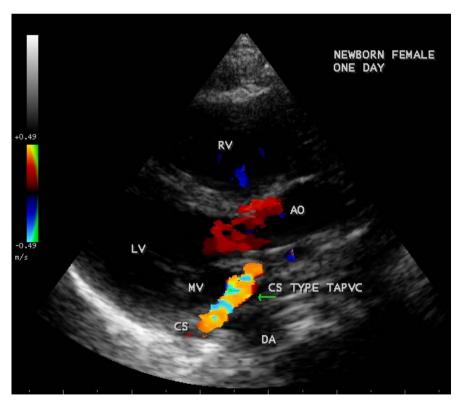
Parasternal long axis view showing the coronary sinus ASD (atrial septal defect) with total anomalous pulmonary venous connection (CS type TAPVC) in a new born.
